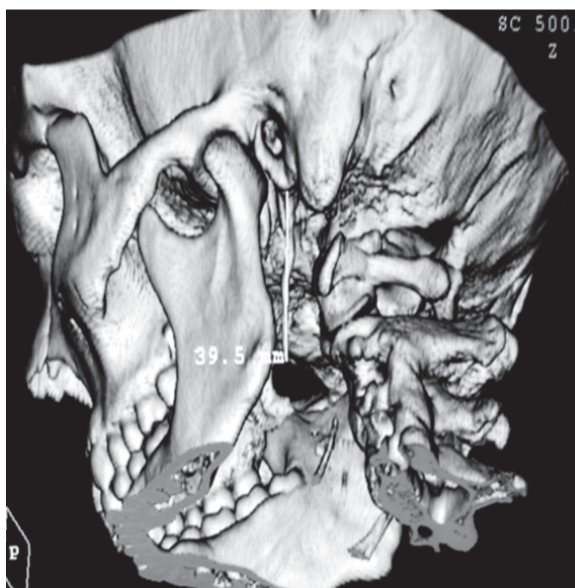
Left styloid process of a 24-year-old case with Eagle syndrome on 3-D computed tomography images with a length of 39.5 mm is observed as longer than normal.
